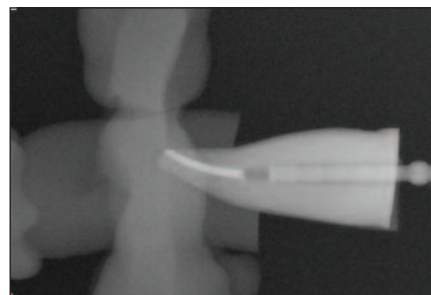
Same tooth radiographed with a popular radio-apparent fiber post.
